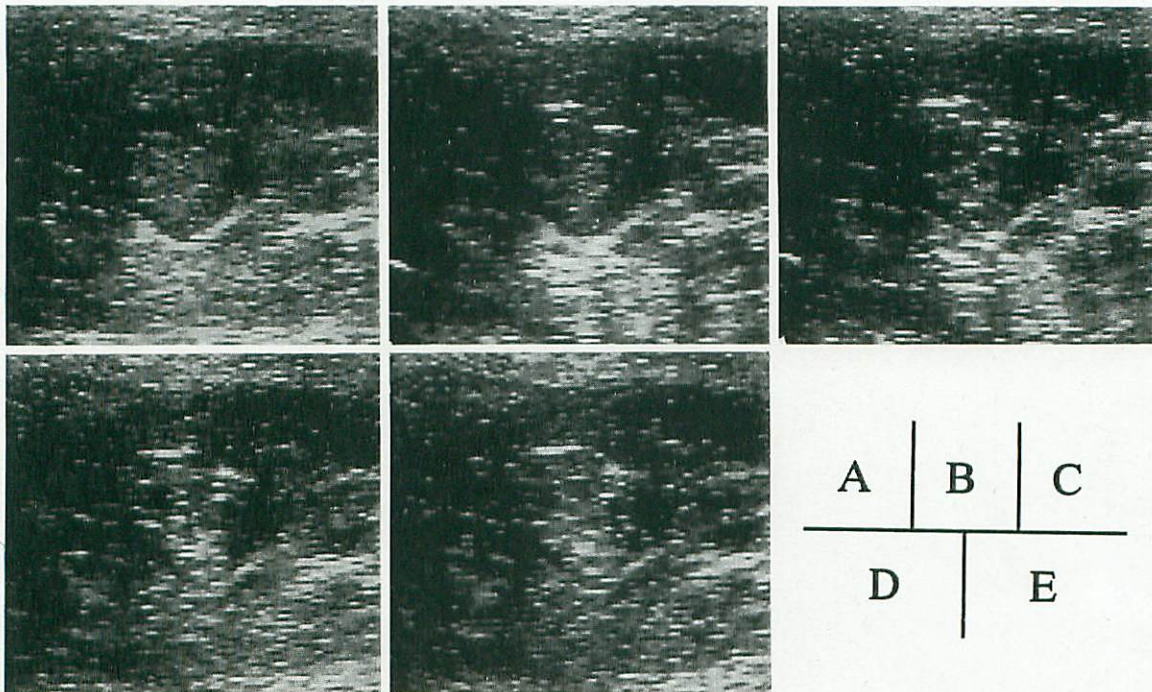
A to E: Serial ultrasonograms of the renal mass obtained before (A) and after (B-E) injection of contrast medium. Moderate enhancement of the mass is evident, except in the peripheral hypoechoic area.
